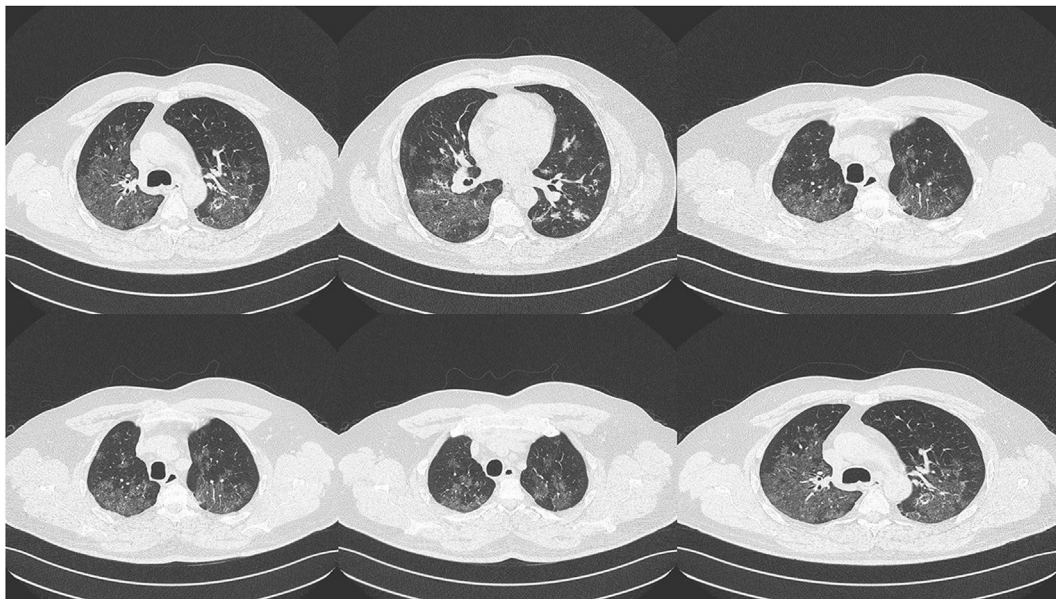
CT scan of the thorax upon admission.
